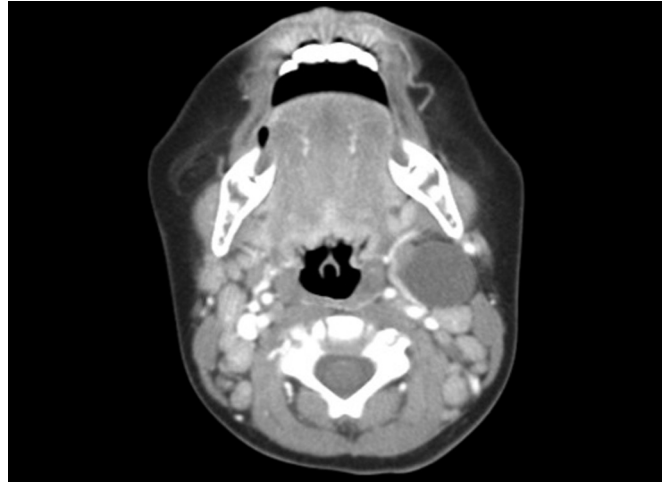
Computed tomographic scan showing a second branchial cleft cyst.
